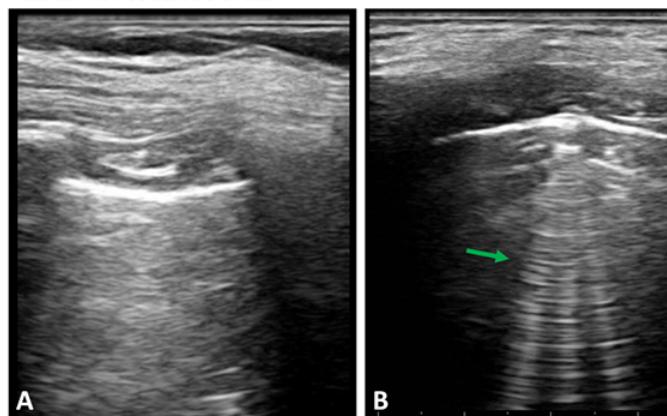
The score lung ultrasound evaluation in dermatomyositis patient with a total of B-lines to equal 8: (A) Left anterior axilar recess, without B-line and (B) Right posterior axilar recess, with B-lines (arrow).
